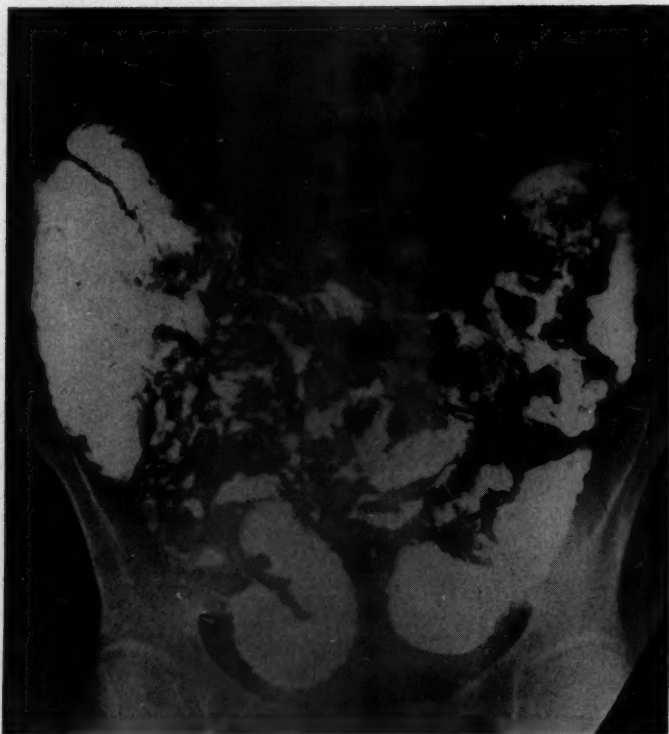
Deficiency pattern in roentgenogram of small intestine made September 18, 1953, showing puddling, segmentation, and coarsening of mucosal folds.
